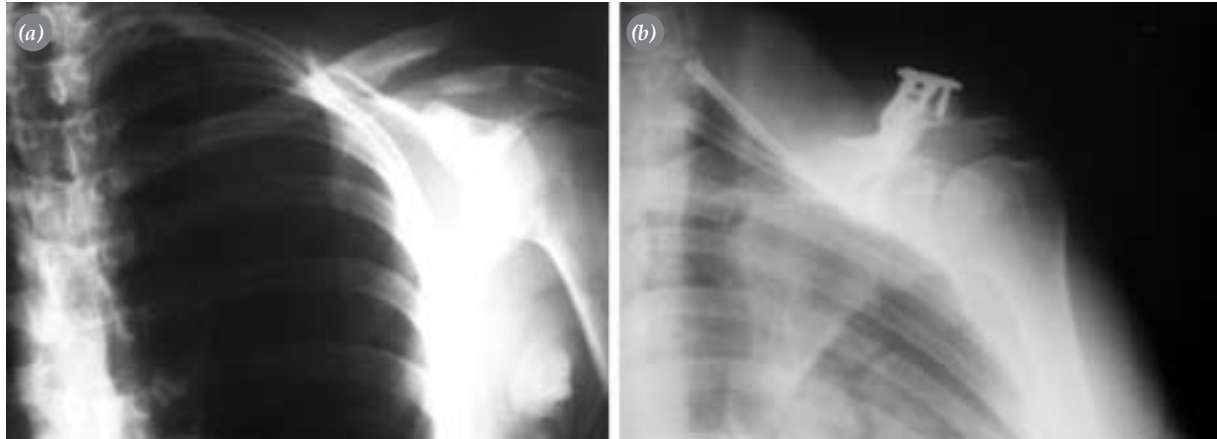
(a) Type II lateral end clavicle fracture which occurred after a simple fall, (b) Oblique X-ray showing healed fracture, relation of lateral clavicle to acromion and position of the plate.
